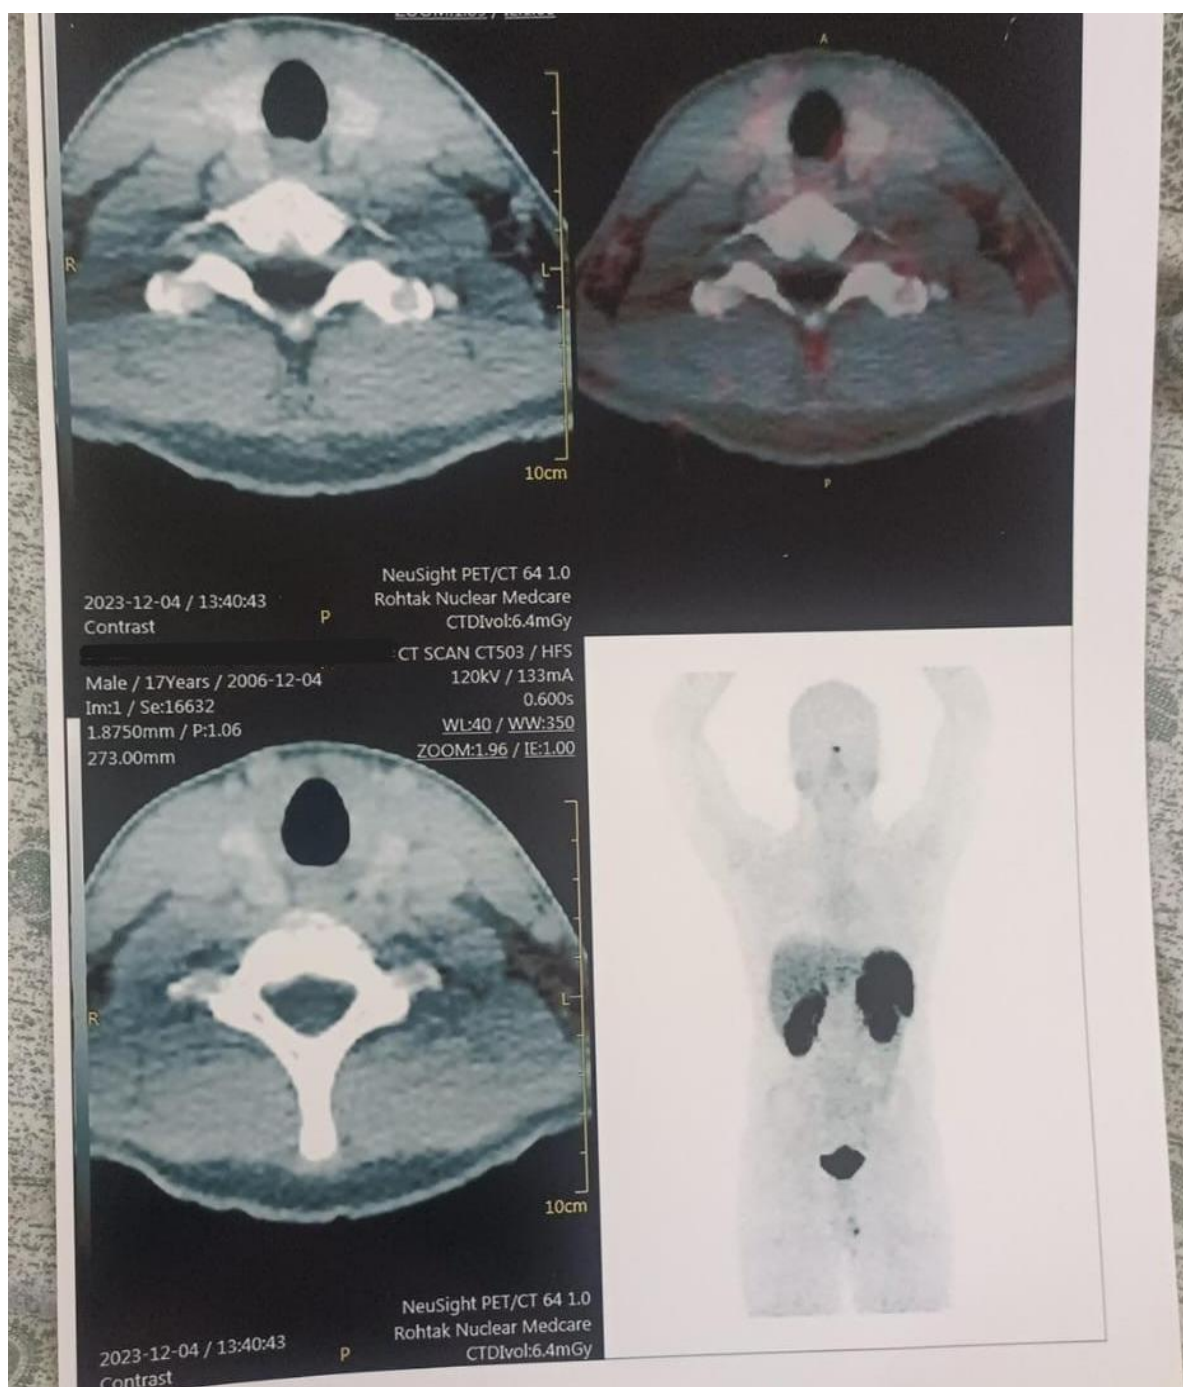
PET/CT Imaging of the Cervical Spine and Thoracic Region in a 17-Year-Old Male
